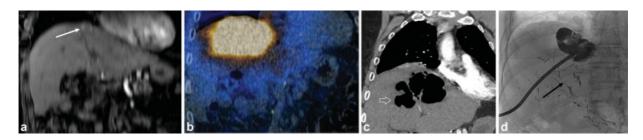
Infected biloma complicating radioembolization. A 65-year-old man with recurrence following partial hepatectomy and pancreaticoduodenetomy for metastatic pancreatic neuroendocrine tumor. Contrast-enhanced coronal MR image demonstrates a segment 4 metastatic tumor (white arrow) (a). The lesion was treated with ablative-dose segmental radioembolization (radiation segmentectomy); posttreatment bremsstrahlung-fused coronal SPECT/CT image reveals deposition of the Y-90 microspheres in the target segment (tan) (b). Despite a 3-week course of prophylactic oral antibiotics, the patient returned with fevers and pain 3 months after treatment. Coronal image from CT chest shows a large intrahepatic abscess (arrow = gas in the abscess cavity) (c). This was treated with antibiotics and percutaneous drainage. At a subsequent drain revision, injection of the abscess catheter reveals communication with the bile ducts (black arrow) (d). Ultimately, the infected biloma resolved, the drain was removed, and the metastatic tumor showed complete response.
